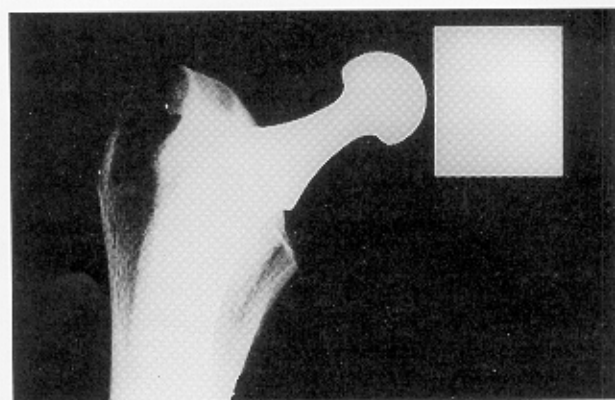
Radiograph of arthroplasty model; horizontal width of slip gauge 30 mm.
